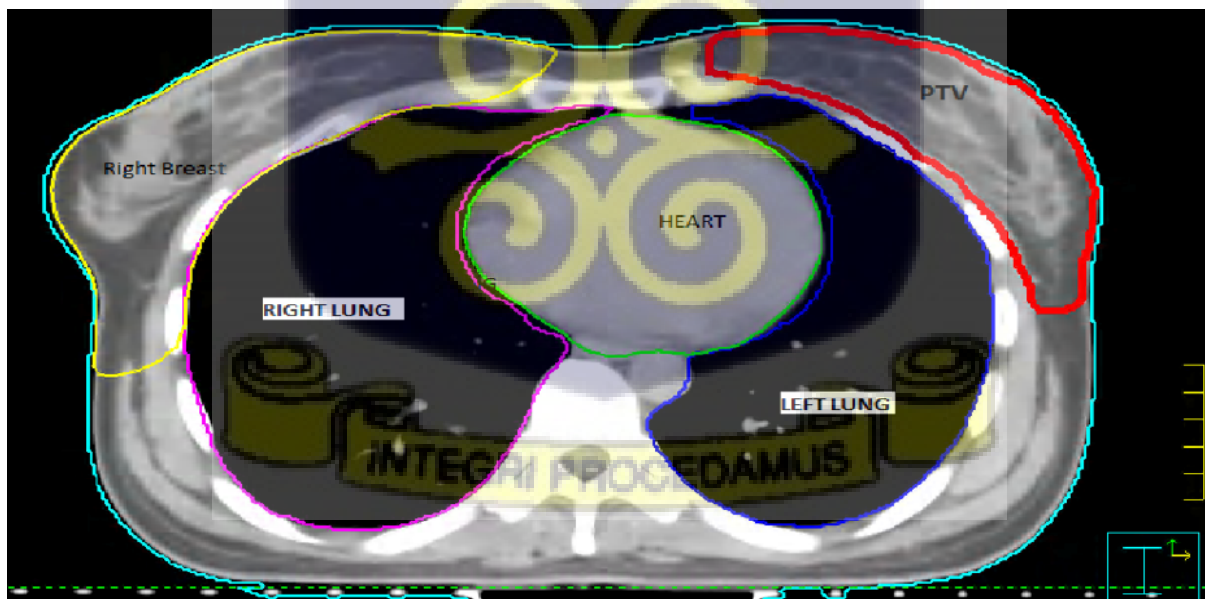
Transverse view of a contoured CT image indicating the target volume and organs at risk.
